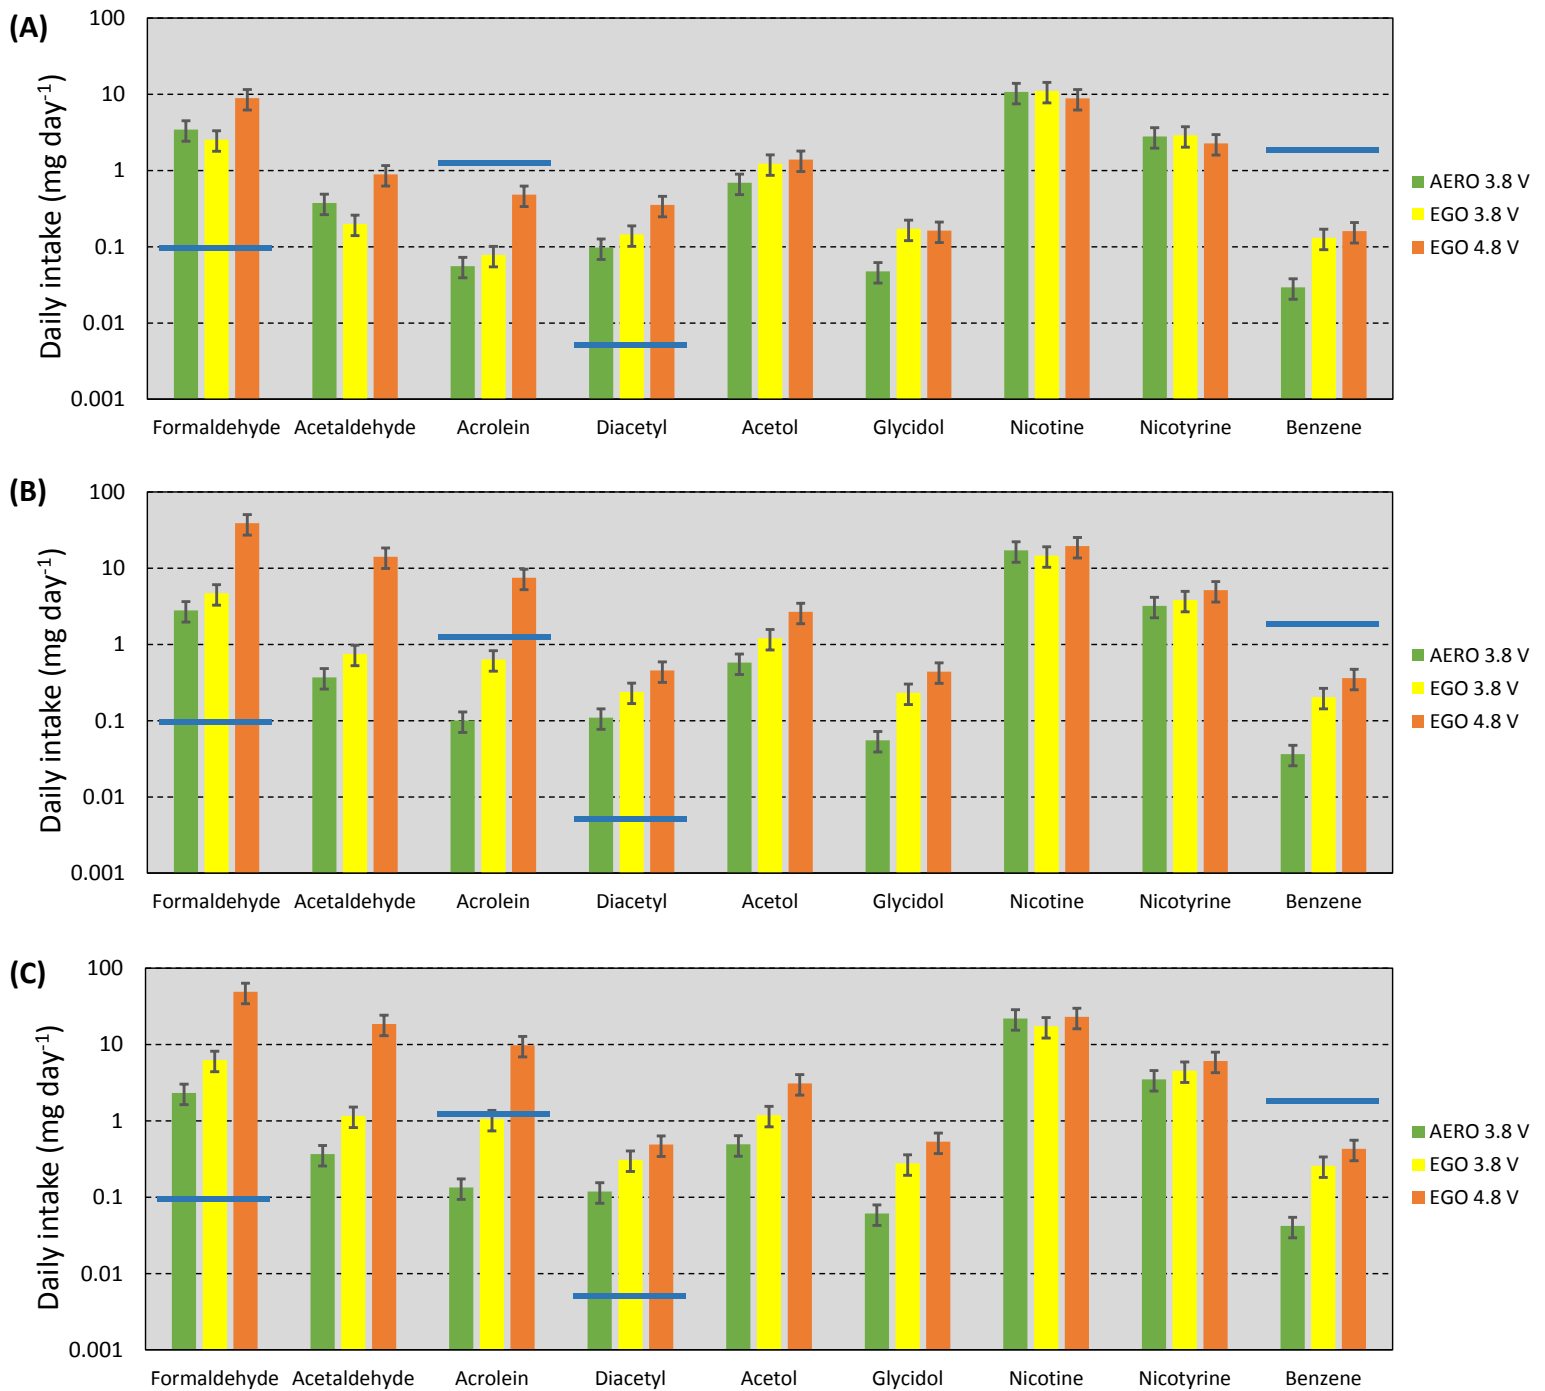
Impact of the choice of vaporizer and voltage used to consume the CT e-liquid on the mass intake predicted for a high-usage rate of 250 puffs per day, distributed in (A) 25 sessions of 10 puffs each; (B) 10 sessions of 25 puffs each, and (C) 5 sessions of 50 puffs each. The blue lines correspond to daily doses derived from occupational health guidelines.
